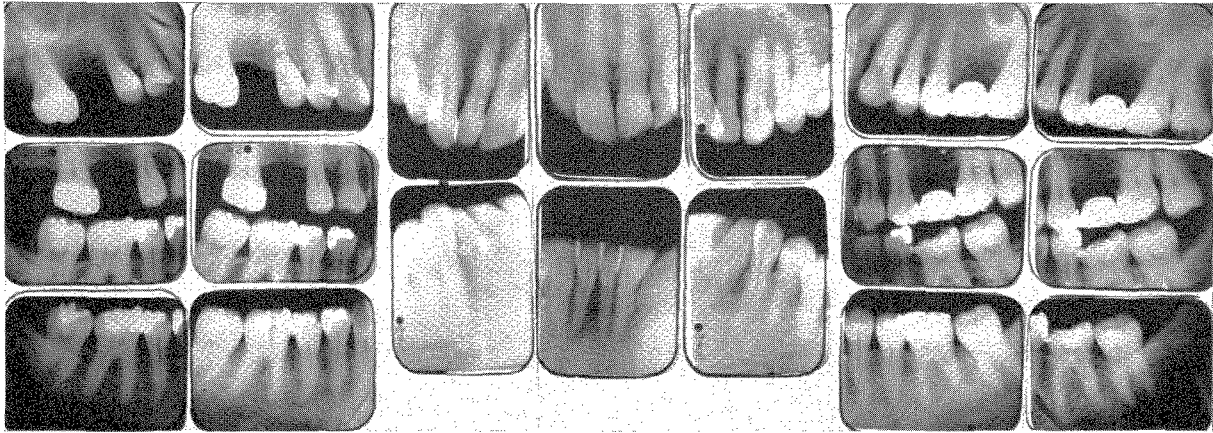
Roentgenograms taken in 1958 when the patient was 55 years of age, showing excellent structures in spite of deep vertical overlap, missing teeth, and malocclusion.
